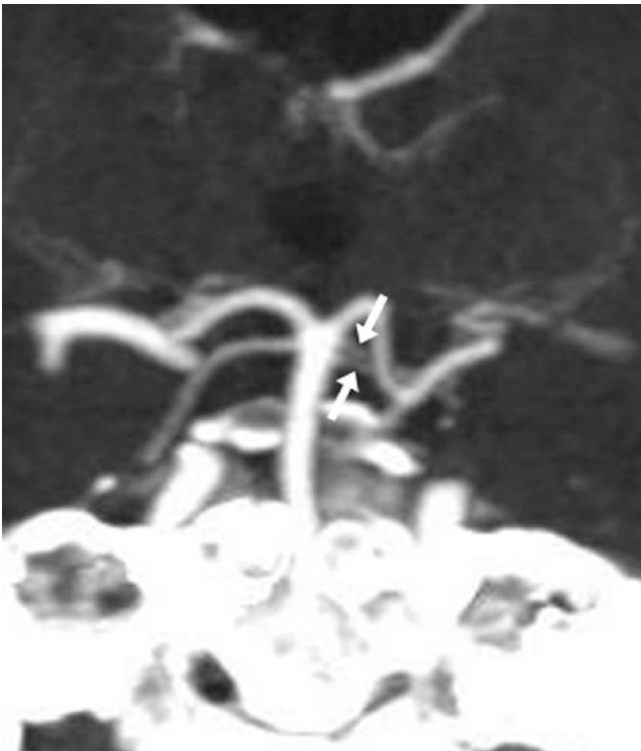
85-year-old with left SCA duplication (*arrows*) on a 5 mm-thickness coronal MPR from a CTA
